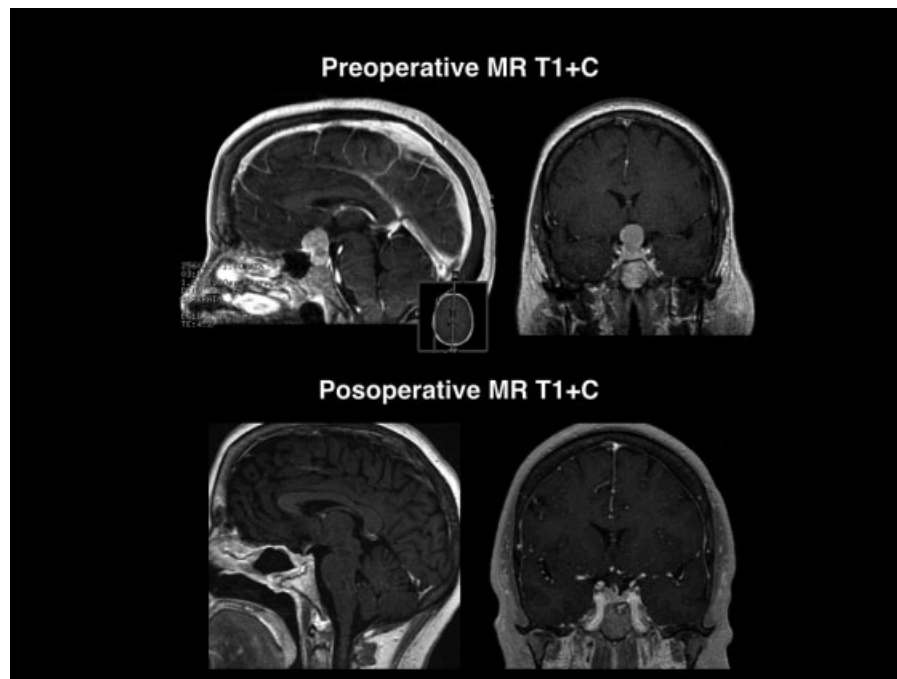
Pre- and postoperative magnetic resonance imaging showing complete resection and no recurrence in 4 years.
